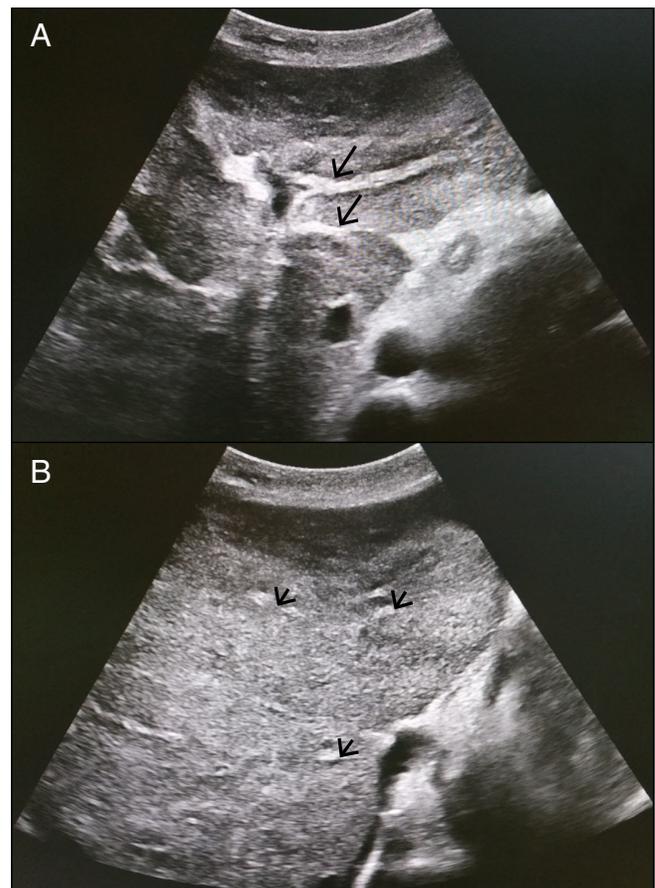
Ultrasound of the abdomen showing (A) the irregular surface of the liver and hyperechoic thickened walls of the main portal vein (arrows), and (B) thickening of the portal vein branches and venules (arrows), giving a Symmer's pipe-stem pattern of periportal fibrosis.
